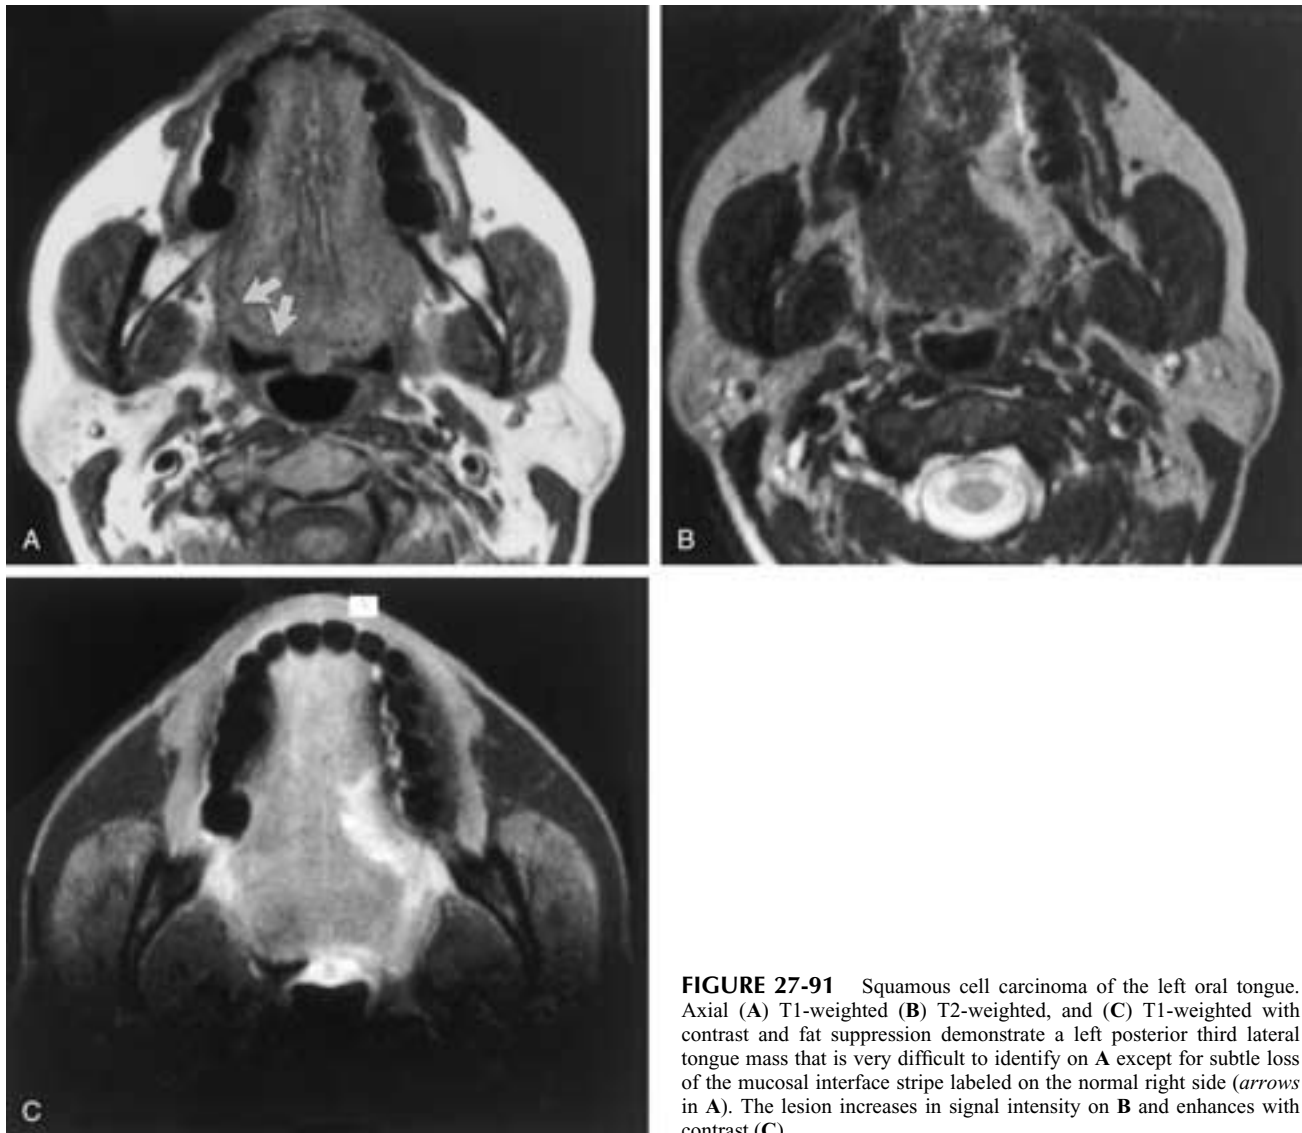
Squamous cell carcinoma of the left oral tongue. Axial (A) T1-weighted (B) T2-weighted, and (C) T1-weighted with contrast and fat suppression demonstrate a left posterior third lateral tongue mass that is very difficult to identify on A except for subtle loss of the mucosal interface stripe labeled on the normal right side (arrows in A). The lesion increases in signal intensity on B and enhances with contrast (C).
